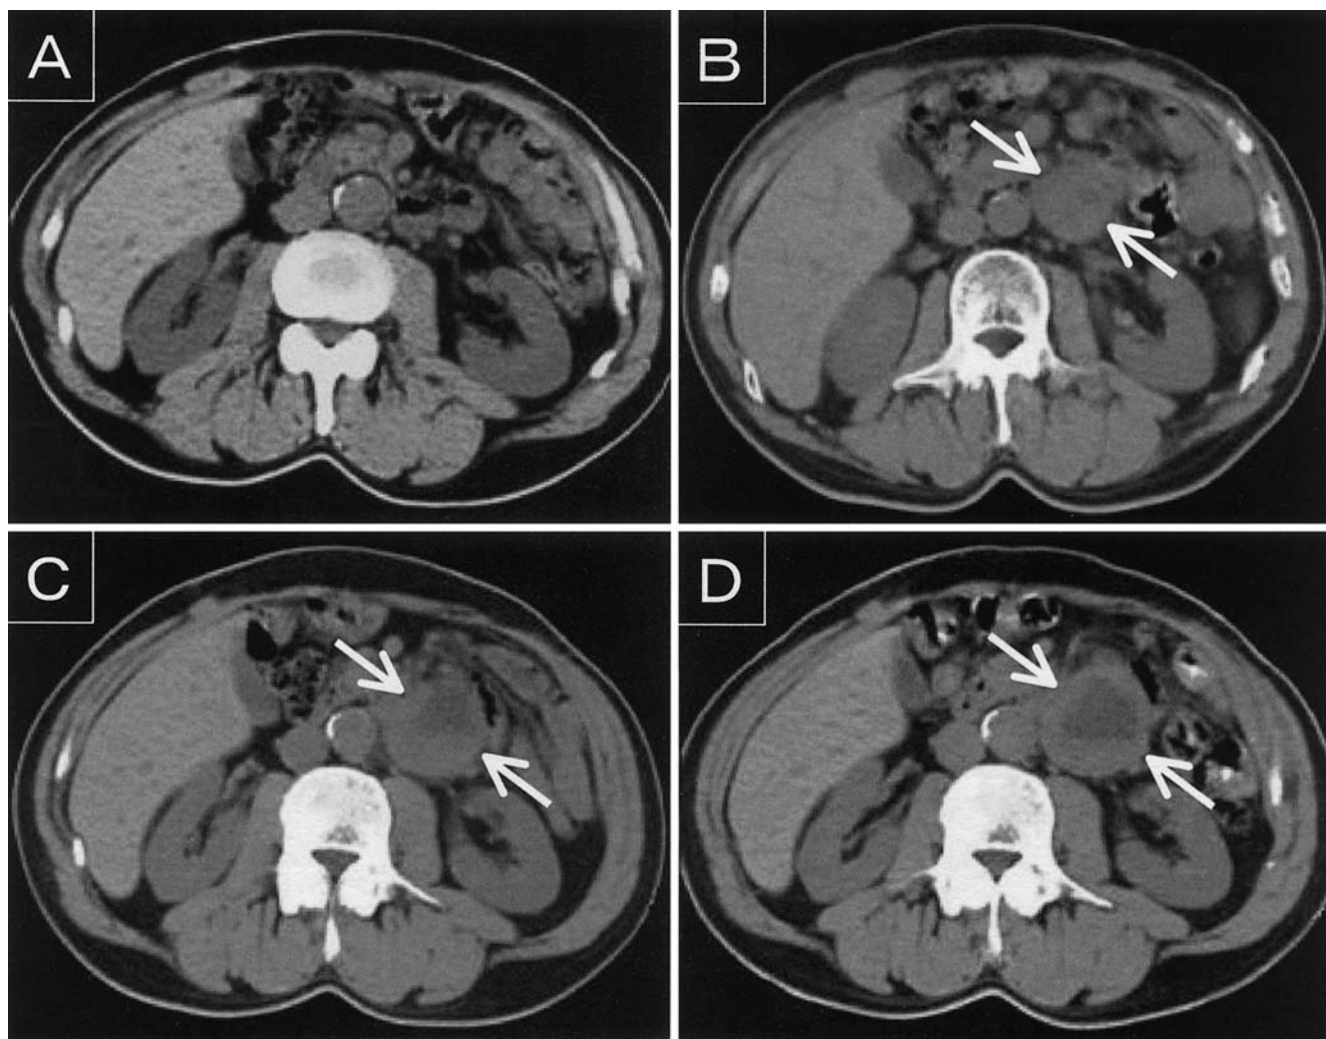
Serial computed tomography (CT) scans. A At 24 months after the first operation, no recurrence was detected. B At 30 months, 3 months after the initiation of imatinib dose reduction, a 4-cm tumor was detected (*arrows*). C Two months after the time the scan shown in B was taken, the tumor size had increased (*arrows*). D At 35 months after the first operation, the tumor was 6cm in diameter (*arrows*). The patient then underwent reoperation
